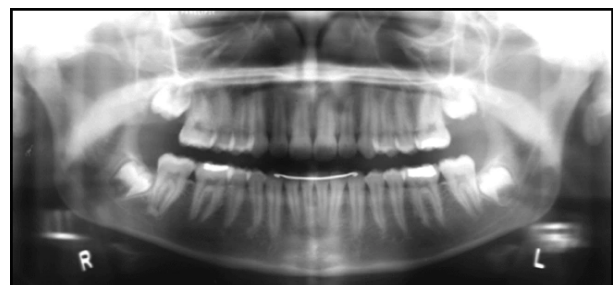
Panoramic radiograph demonstrating the effect that occurs when the lips are not closed during exposure resulting in an area of increased radiolucency in anterior crown regions.
